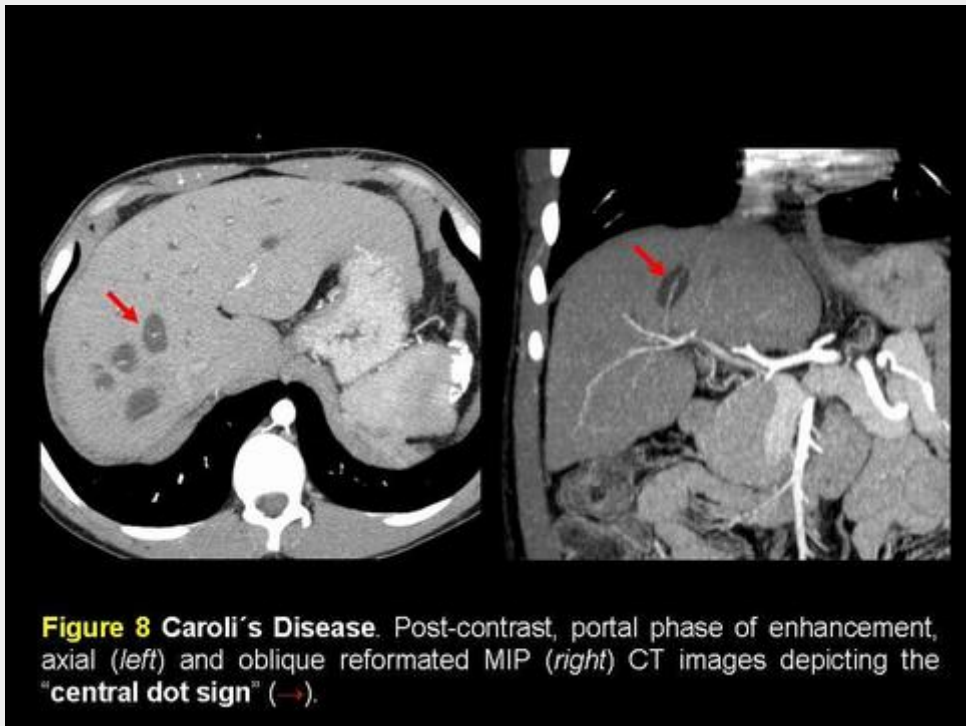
Caroli's Disease. Post-contrast, portal phase of enhancement, axial (*left*) and oblique reformed MIP (*right*) CT images depicting the "central dot sign" (→).
